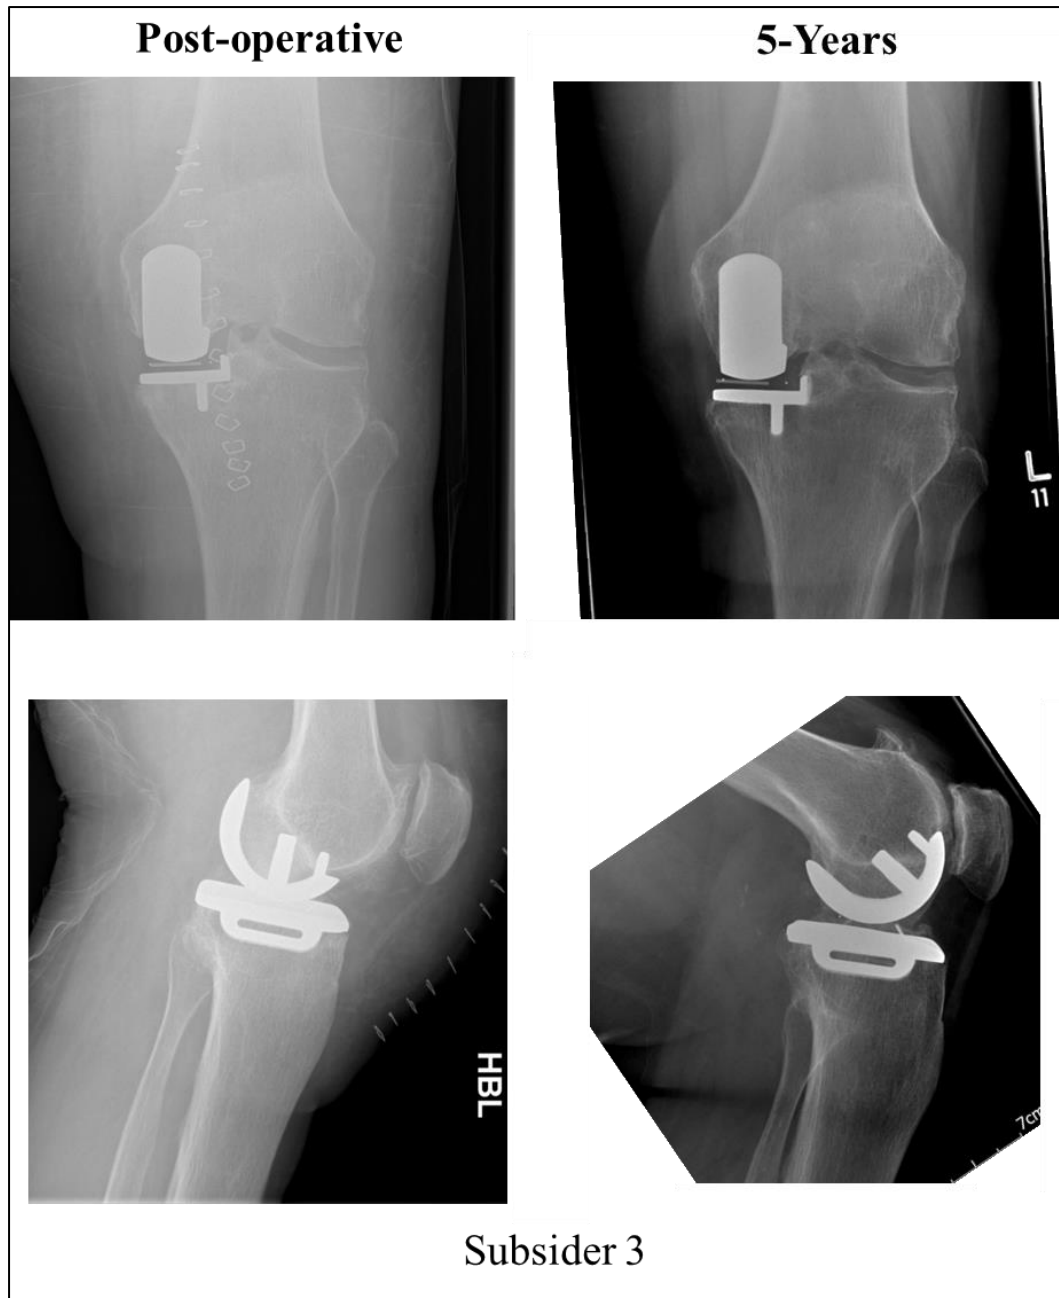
Post-operative and five-year radiographs for Subsider 3.
